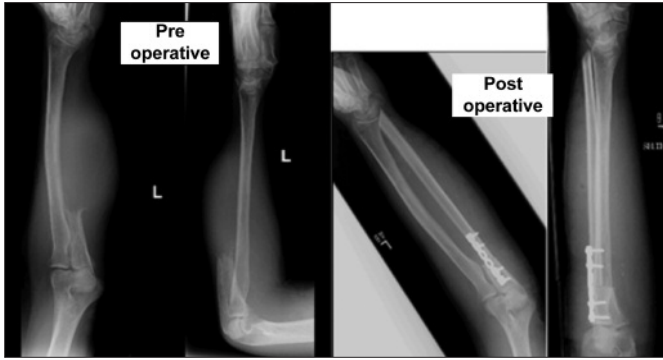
Pre-operative X-rays at the time of presentation before wide margin excision. Postoperative X-rays after excision of tumour and reconstruction with vascularised free fibula.
